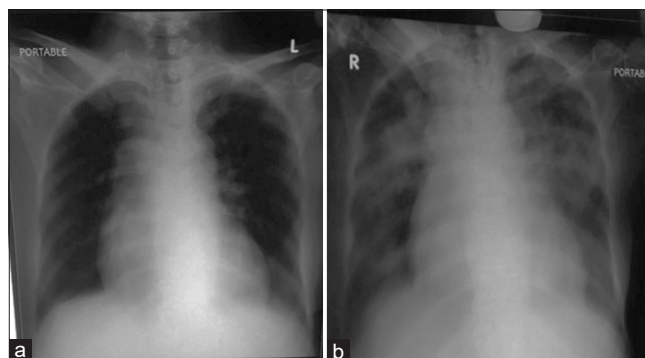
Chest X-ray (bed-side portable) before transfusion (a). Chest X-ray (bed-side portable) of the same patient after transfusion (b)
